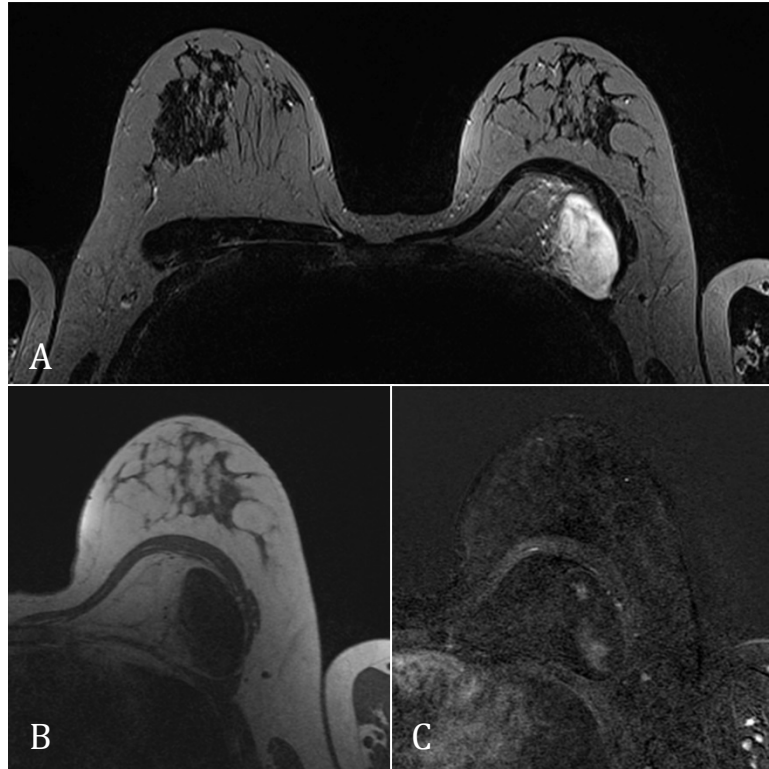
47-year-old BRCA2-positive patient in the high-risk surveillance program with MRI. T2-weighted turbo spin echo (A), T1-weighted gradient echo before contrast administration (B), and subtraction image (C) showing a large interpectoral liposarcoma on the left side.
